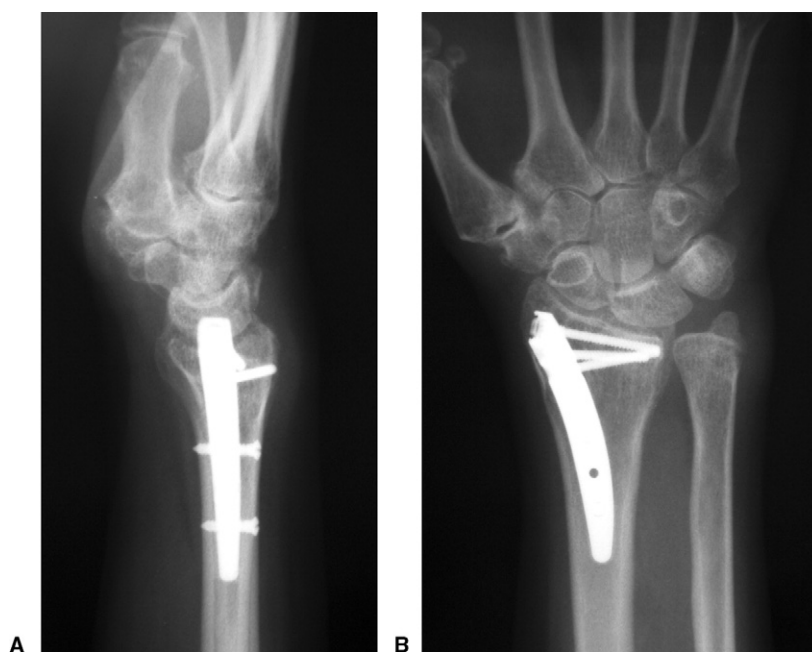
A Lateral and B posteroanterior postoperative radiographs of the patient in Figure 1.
